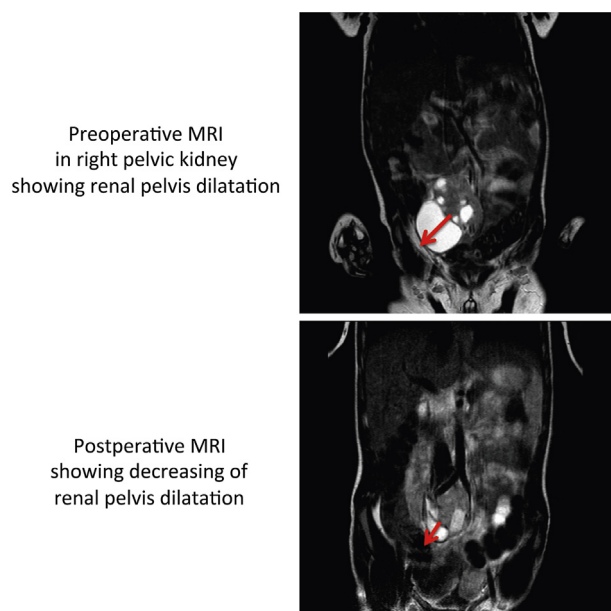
Top: Preoperative MRI in right pelvic kidney showing renal pelvis dilatation. Bottom: Postoperative MRI showing decreasing renal pelvis dilatation.
